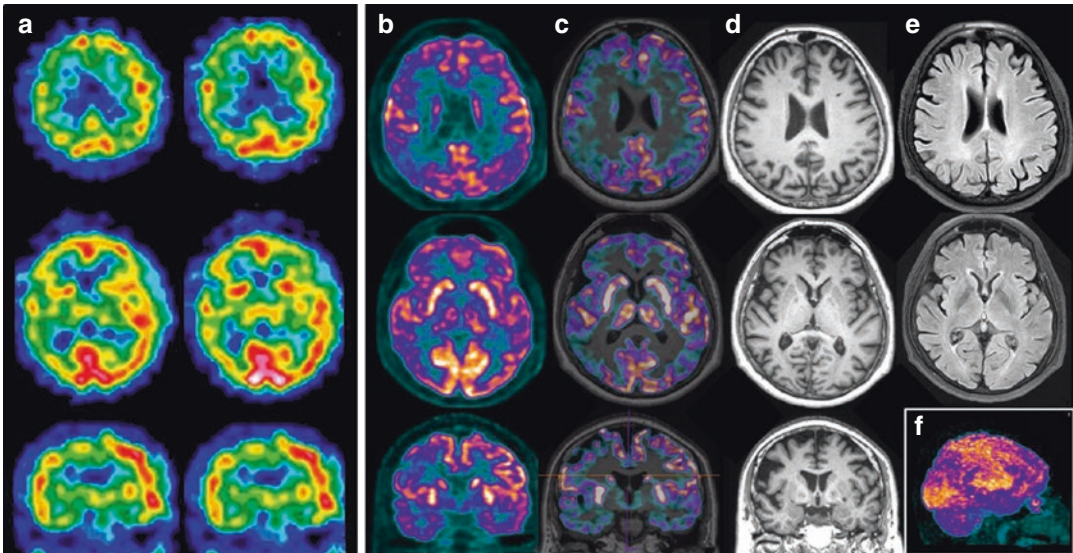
In the left column (a), axial and coronal SPECT views of a 65-year-old woman examined for suspicion of Alzheimer disease, showing perfusion deficit in right frontal and parietal regions. ^{18}F -FDG PET (b) and PET/MRI (c) better displays a deficit of glucose metabolism in the same areas with further hypometabolism in left
